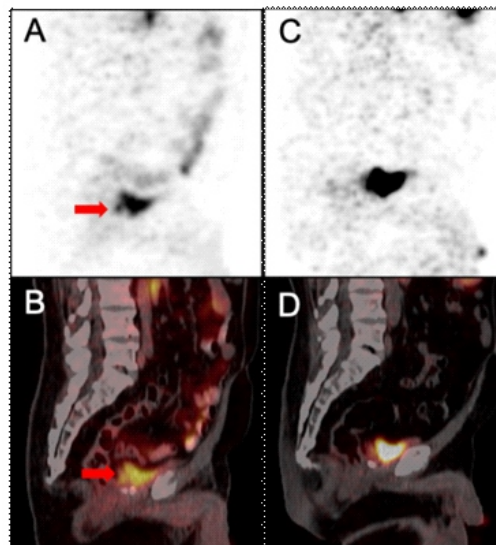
75 year old male, Gleason grade 1, with PSA of 1.51ng/ml. Sagittal ^{18}F -1007-PSMA PET (A) and fused (B) images demonstrating prostatic recurrence (arrow). ^{68}Ga -PSMA-11 sagittal PET (C) and fused (D) images demonstrating negative uptake.
